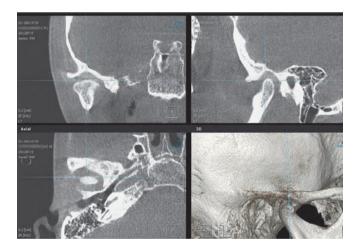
CBCT (Picasso, Orange Dental) with the COPA in place, showing a physiological condyle position 20 .
